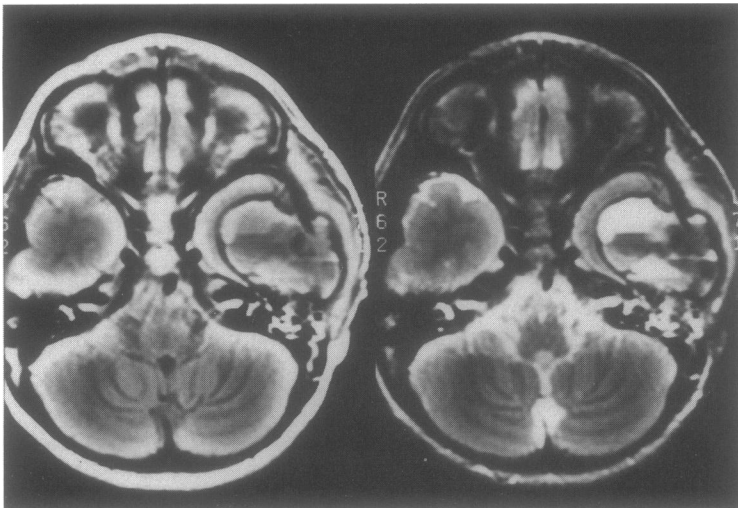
MRI of the head of the same patient in Figure 1. The fluid-fluid levels are clearly demonstrated.
